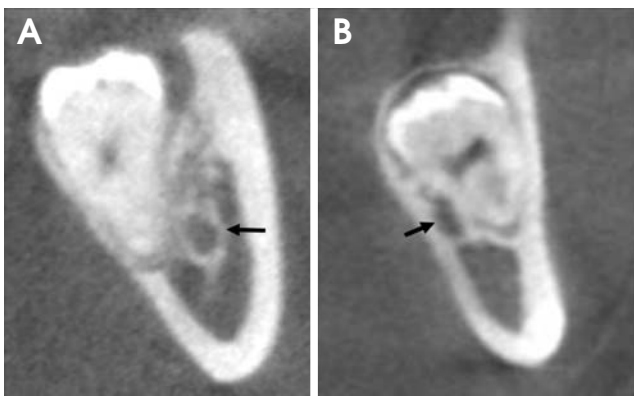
A. Darkening of the root is actually the increased radiolucency of the root of the third molar where the mandibular canal crosses it on the panoramic radiograph. B. No darkening of the root is seen.
